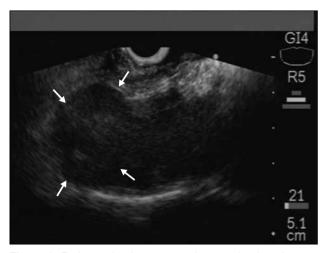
Endoscopic ultrasonography examination shows a diffusely enlarged and irregular mass at the head of the pancreas (white arrows).
